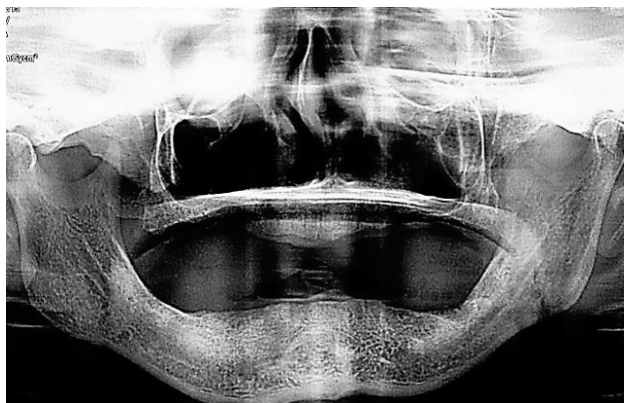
Pre-operative orthopantomograph
